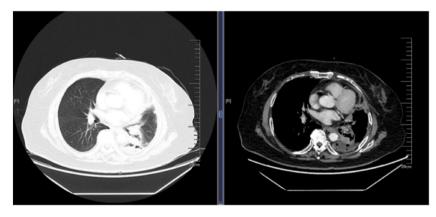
Contrast-enhanced CT images taken on 21 April 2021 showed a patchy high-density shadow in the left lower lobe and multiple pleural nodules.
